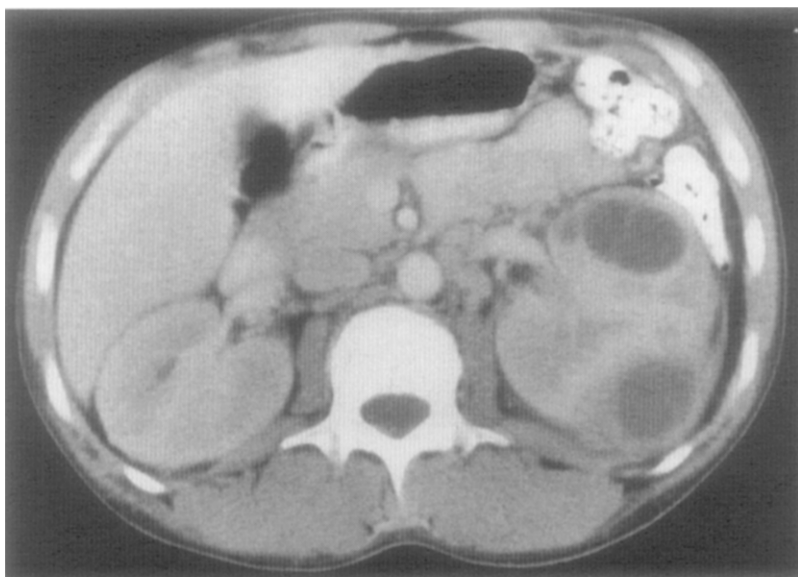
Abdominal CT scan. Enlarged left kidney with multiple sharply outlined hypodensities.
